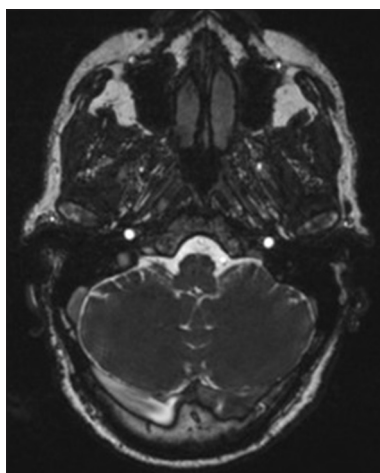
Preoperative axial true fast imaging with steady-state-free precession magnetic resonance imaging: Neurovascular conflict between left vertebral artery and glossopharyngeal nerve.
